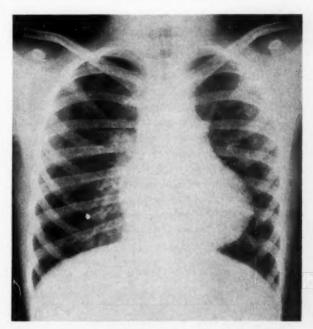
Posteroanterior roentgenogram of the chest reveals cardiomegaly, predominantly right-sided.
